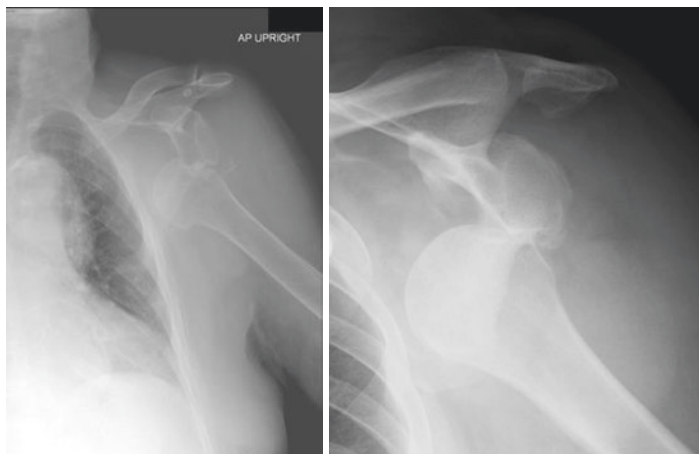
Radiographs of a glenohumeral dislocation. As discussed, it is essential to always examine X-rays for associated fractures, which can help in determining the risk for future instability events and the need for operative intervention
